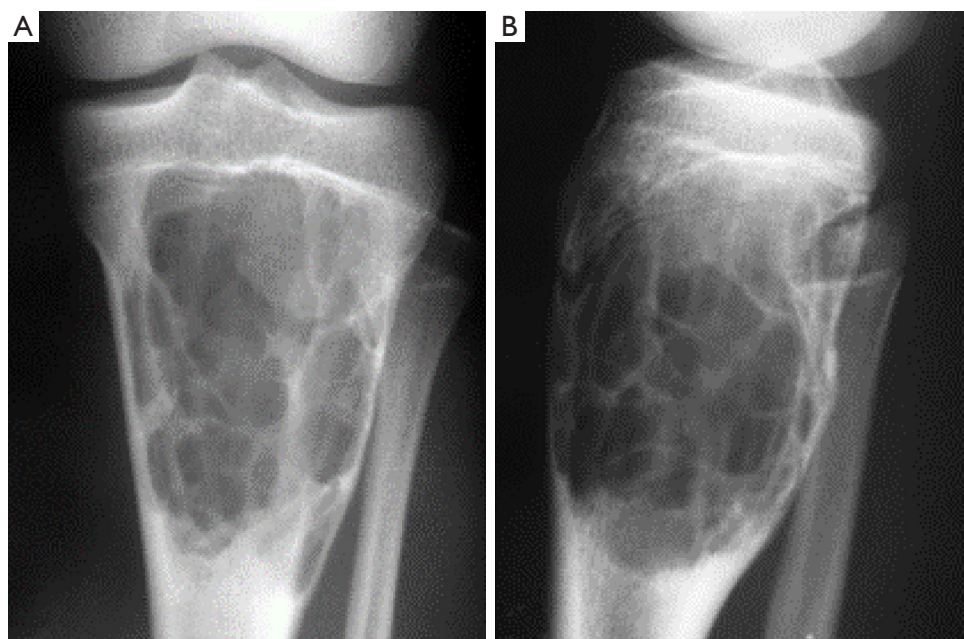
Giant cell tumor of the bone. Plain radiography of the anteroposterior (A) and lateral positions (B) showed an expansile lesion with multiple cysts at the metaphysis of the proximal tibia. Some coarse bony ridges were inside the lesion, and the lesion did not break the epiphysis.
